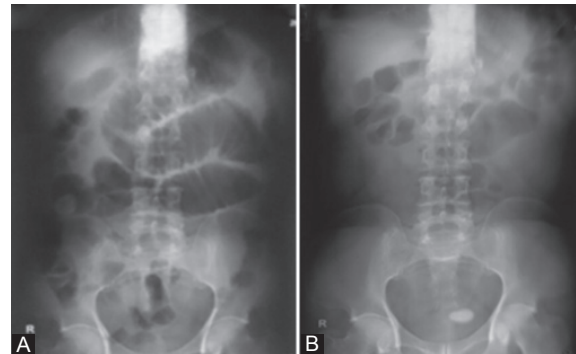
A) X-ray of the abdomen shows multiple air fluid levels with a radio-opaque shadow on the right side of the abdomen. B) X-ray of the abdomen demonstrates multiple air fluid levels with a radio-opaque shadow in the pelvis.
